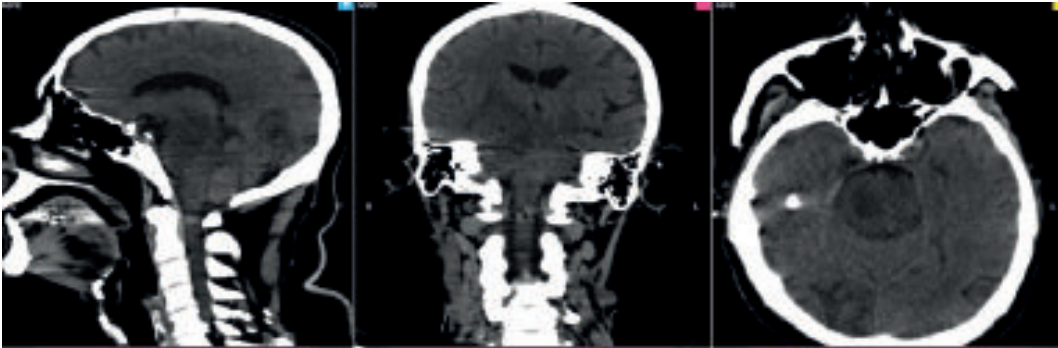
CT scan of brain showing metastasis of tumor to brain near the brainstem.
